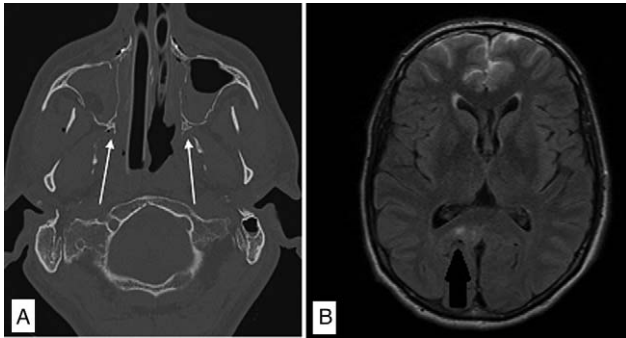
(A) Immediate postoperative computed tomography scan axial cut showing normal jaw osteotomies, with pterygomaxillary disjunction. (B) Postoperative cerebral and orbital magnetic resonance imaging axial cut showing slight flair hypersignal in the right internal occipital cortex and in the insular right parenchyma.
